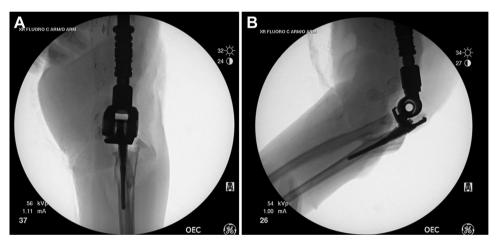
Intraoperative fluoroscopy x-rays. (A) Anteroposterior view. (B) Lateral view.
